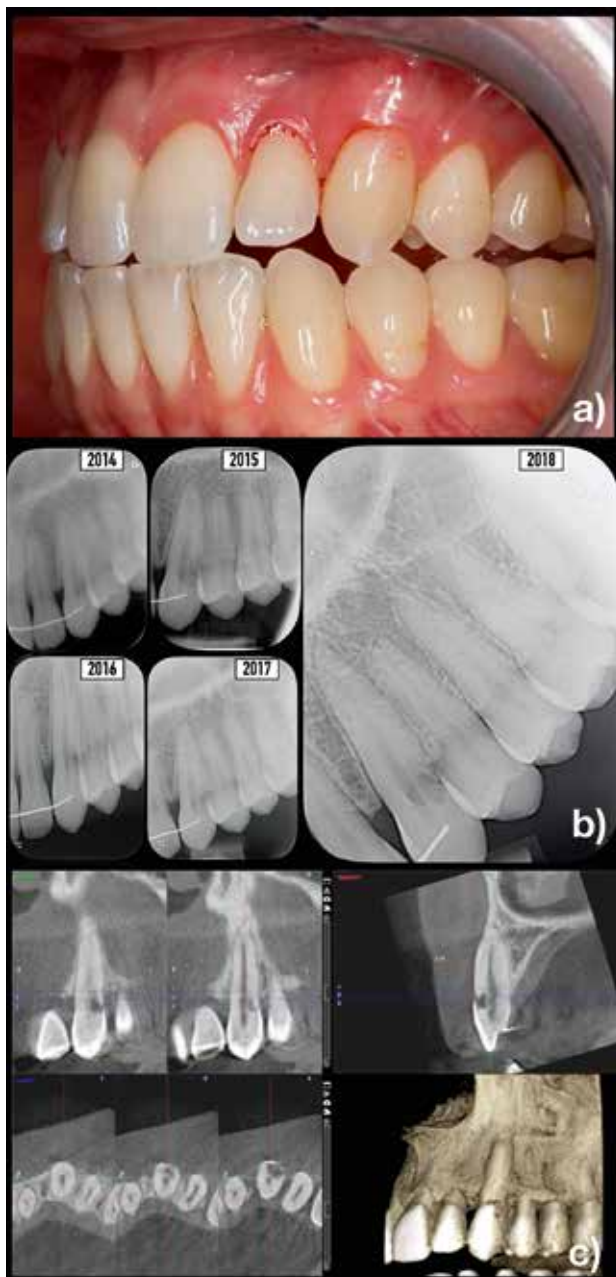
Diagnosis a) initial situation b) radiographic monitoring c) CBCT pre-op.
